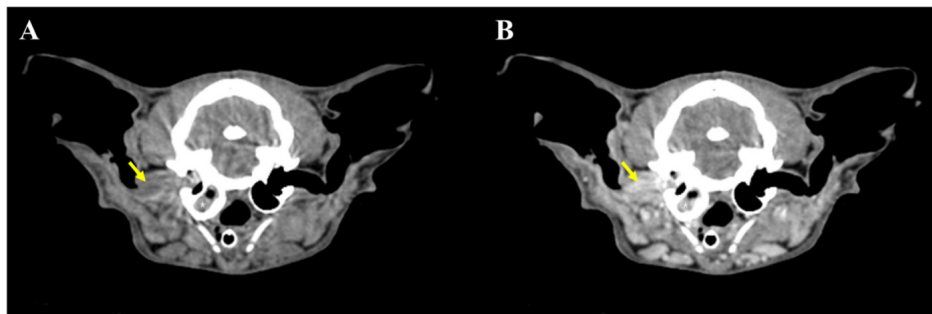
CT findings of an aural polyp on right ear. (A) Before contrast-enhanced, (B) after contrast-enhanced CT scan. Unilateral tympanic bulla discharges (asterisk), and a polyp (yellow arrow) that penetrates the tympanic membrane are visible on right ear.
